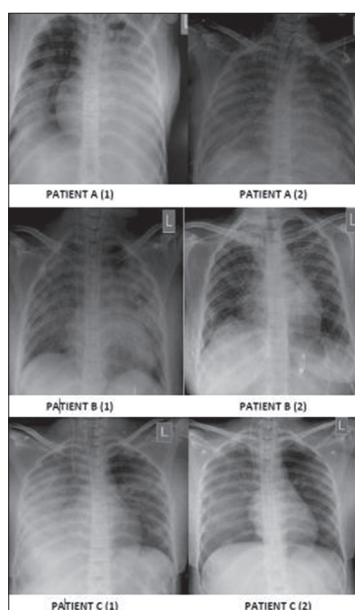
As there are three patients in the study, we included all the X-rays in one figure (which includes, one at admission and one before discharge/death)
